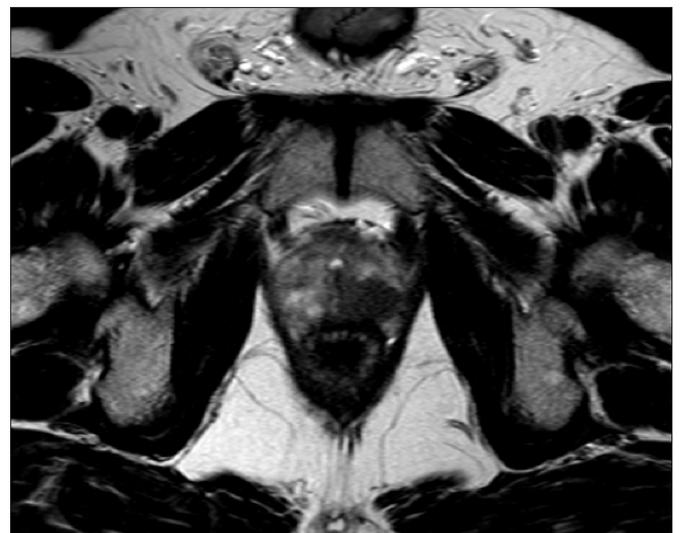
Axial view of T2 weighted MRI of the pelvis, showing cancer as a low signal region in the left posterior aspect of the prostate. As this is a pre-biopsy image, the low signal is not due to haemorrhage.
